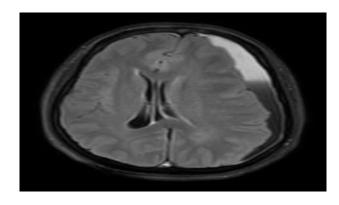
MRI brain, T2 FLAIR sequence, axial section showing acute subdural hematoma along left cerebral convexity with internal fluid levels.
